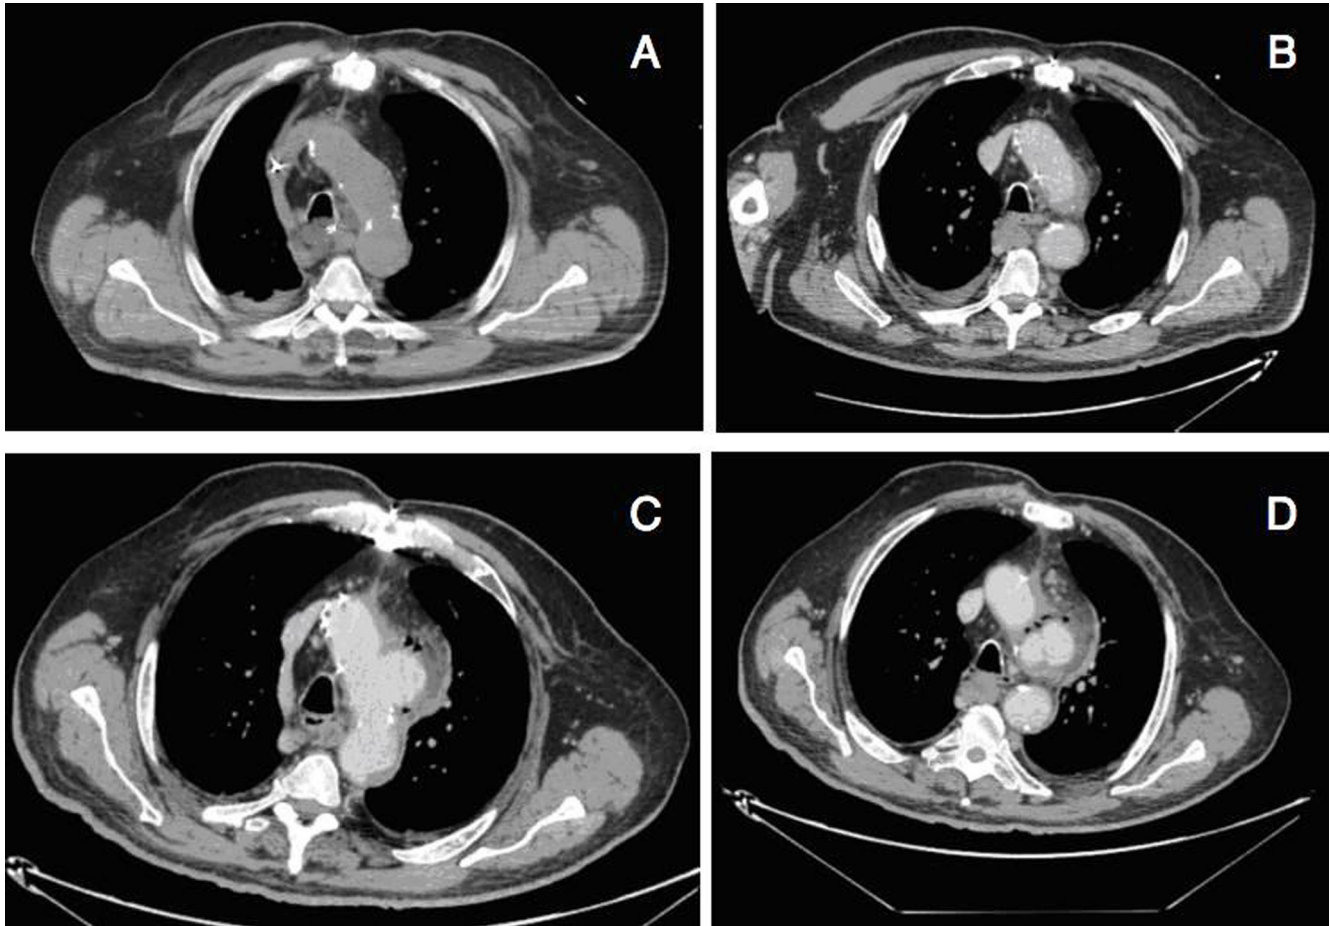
Thoracic computed tomographic scan. Axial images (*Panel A* and *Panel C* same level; *Panel B* and *Panel D* same level). *Panel A.* Day 0, showing a moderately calcified aortic arch. *Panel B.* Day 14, showing the beginning of dilatation of the distal part of the aortic arch with intraluminal hypo-dense material suggestive of thrombus. (*Panel C* and *Panel D*) Day 50, showing a sacciform distal aortic arch aneurysm with air within the aortic wall suggestive of anaerobic infection.
